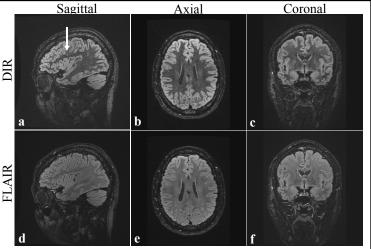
DIR (a-c) and FLAIR (d-f) images acquired using TR=6 sec in a normal volunteer. Note the higher GM/WM contrast and increased conspicuity of a small WM hyperintensity using DIR (arrow).
